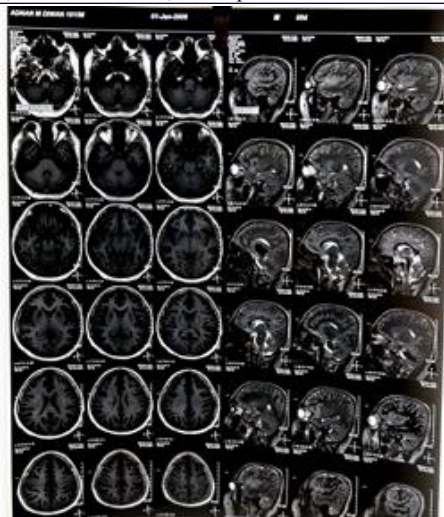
MRI brain showing bilateral basal ganglia hyperintensities.
